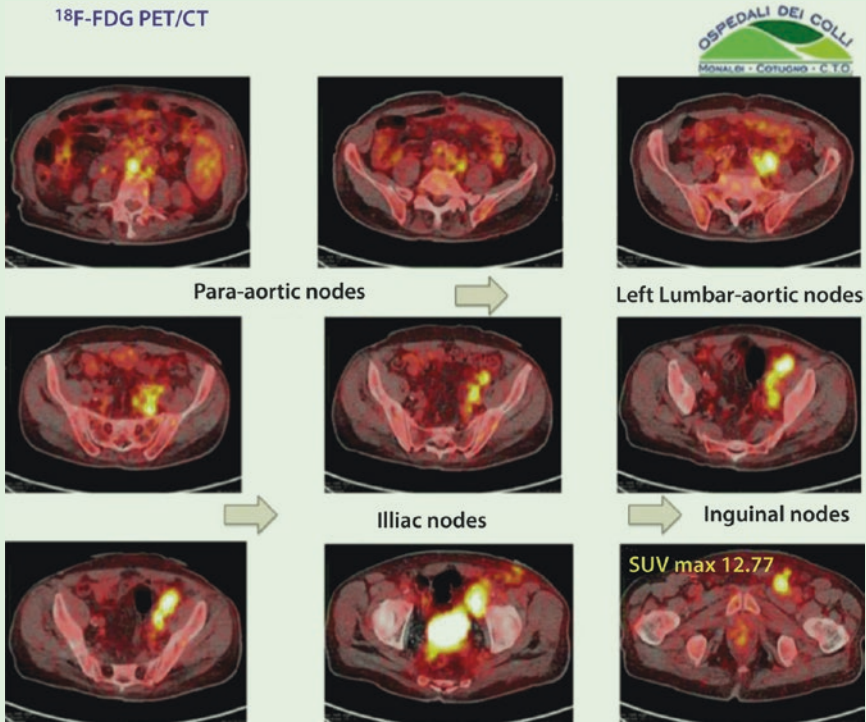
Sequence of transverse reconstruction views at ¹⁸F-FDG PET/CT fusion imaging show severe increase of radio tracer uptake, due to multiple node involvement
